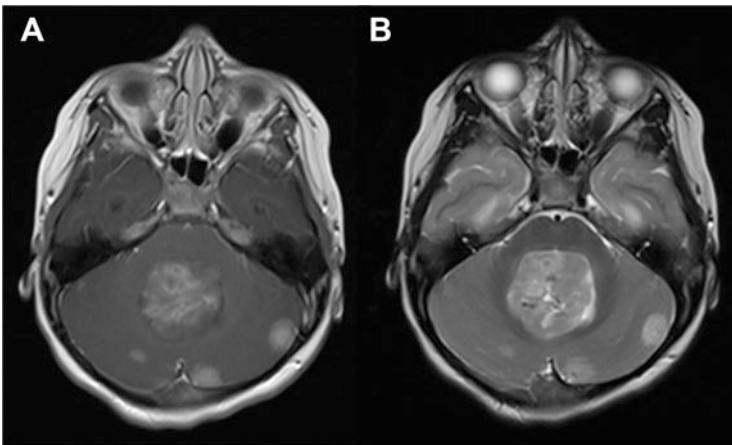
5-year-old with multi-focal MB with a heterogeneous mass in the fourth ventricle and several other enhancing lesions in the posterior fossa. (a) T1 post-gadolinium image. (b) T2-weighted image
